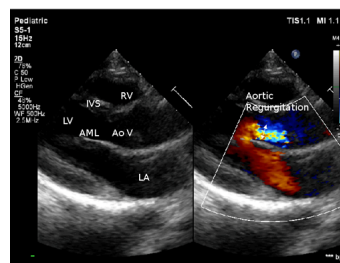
2-D echocardiography with parasternal long axis view showing aortic regurgitation
